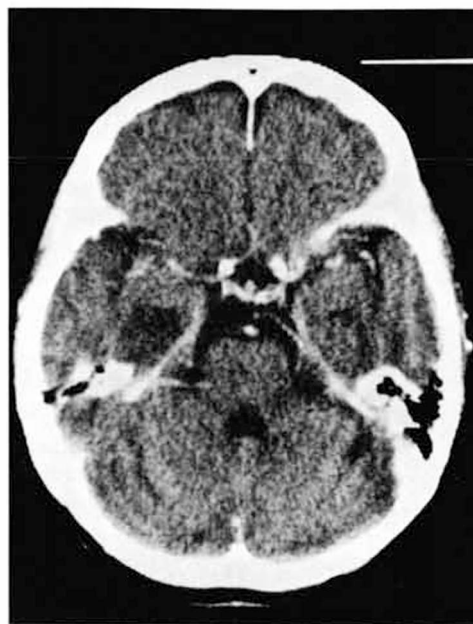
CT scan of patient 2. Infarct in the medial left temporal lobe.
